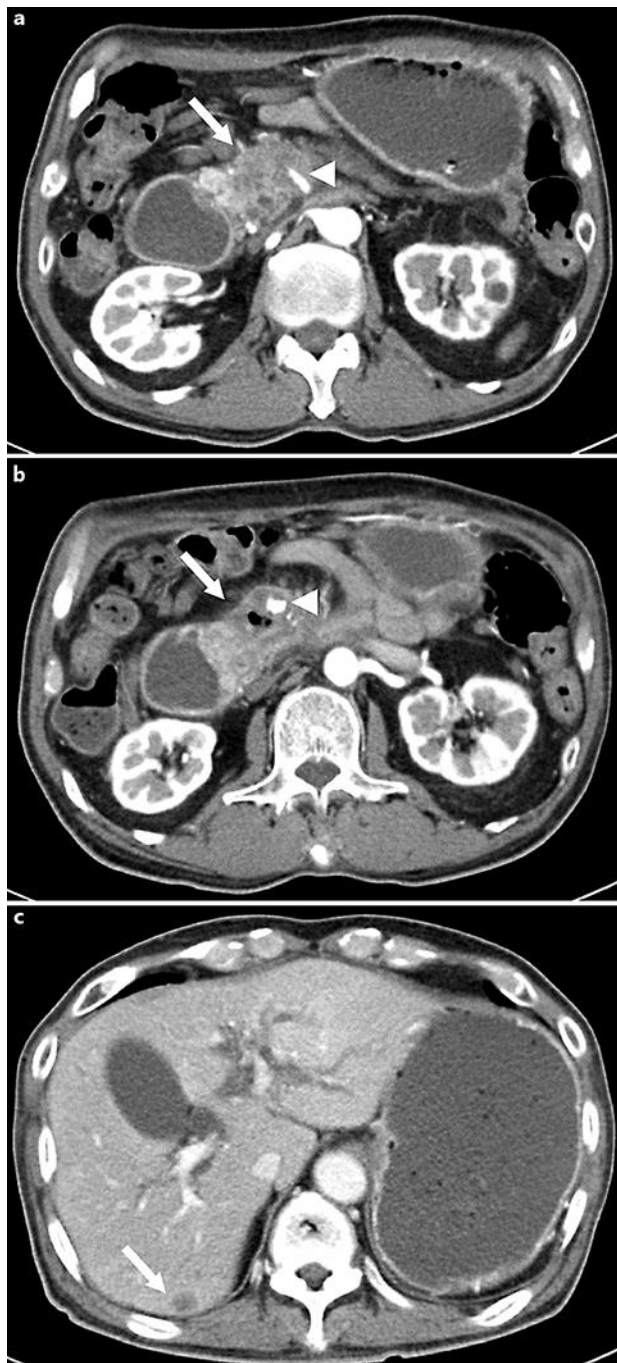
a Enhanced CT shows the hypovascular tumor (arrow) in the uncinate process of the pancreas and dilatation of the stomach and duodenum. The main trunk of the superior mesenteric artery (SMA; arrowhead) is involved in the tumor. b The pancreatic tumor shows air bubbles (arrow). The main SMA trunk (arrowhead) is circumferentially involved in the collapsing tumor. c An intrahepatic low-density lesion, highly suspected to be a metastatic tumor (arrow), and dilatation of the intrahepatic bile ducts are seen.
